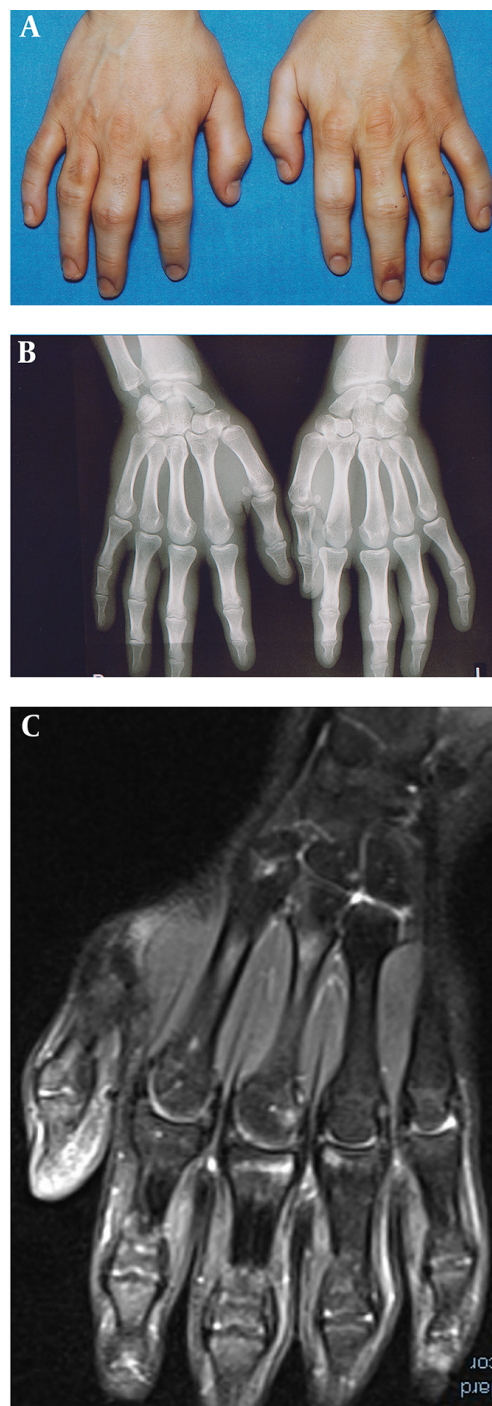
Enlargement of the proximal interphalangeal joints II-IV of the both hand. B, RTG showed soft tissue swelling without bones and joints involved. C, MRI showed dermal edema without synovial inflammation and erosion of the phalangeal bones.
